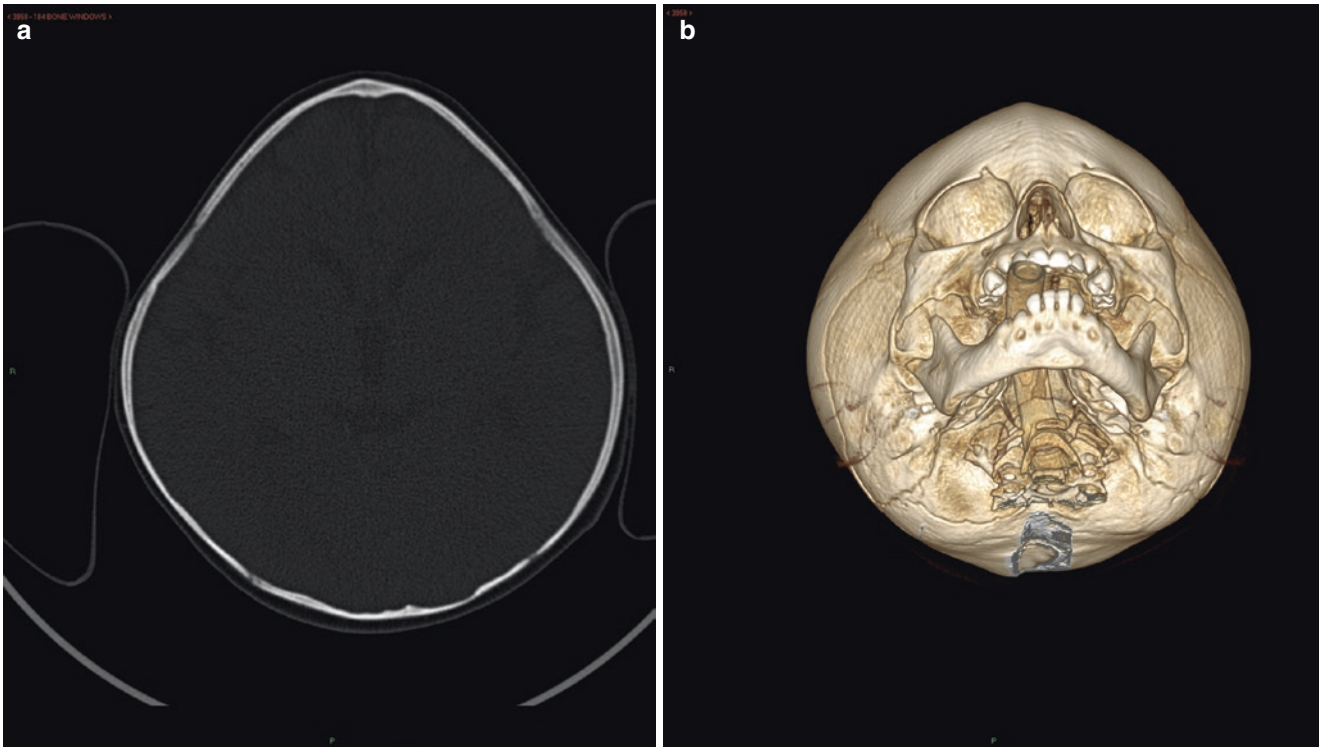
Axial CT (a) and 3D reconstructed (b) images show trigonocephaly due to premature fusion of the metopic suture. Note the typical triangular appearance of the frontal bone, with a prominent midline ridge
